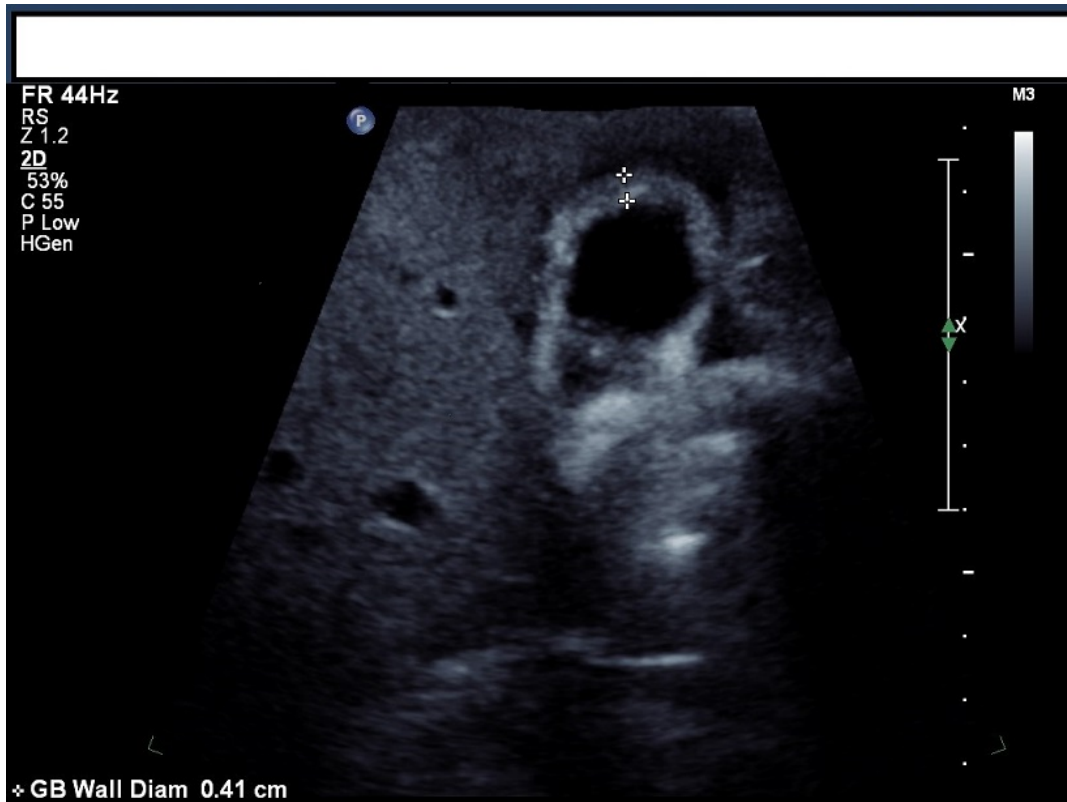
Ultrasound image of the gallbladder findings: thick walled gallbladder and cholelithiasis.
